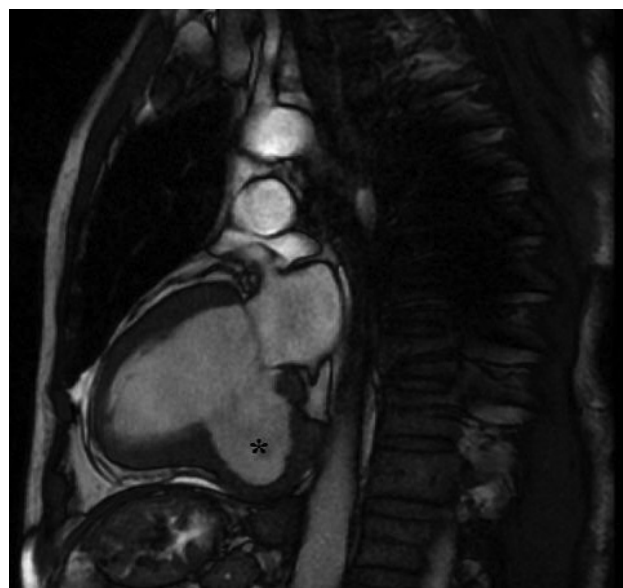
MRI shows a large aneurysm containing some myocardial elements in its wall
